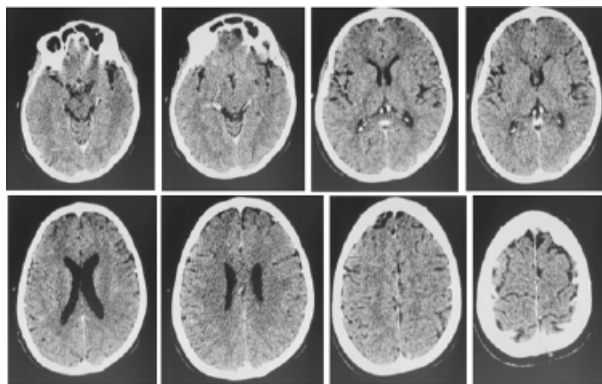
Computer tomography scan of the head was obtained within 25 minutes from the patient's arrival to the ER room, with no early changes seen at the ASPECTS regions.
